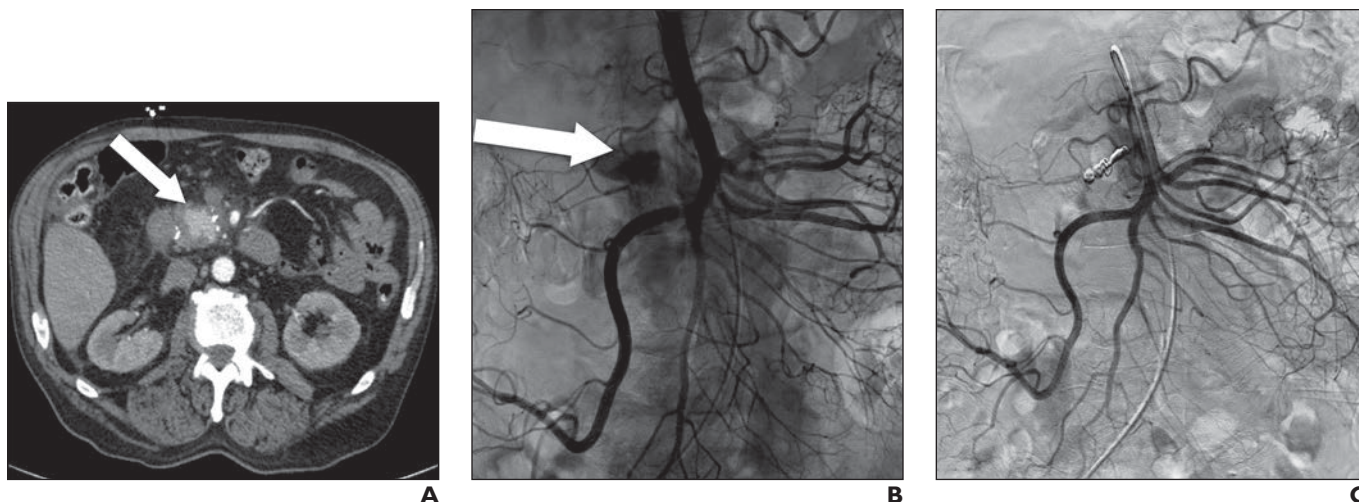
72-year-old man with history of pancreatitis who presented with black stool and decreased hemoglobin level. A, Arterial phase axial CT shows 3.2-cm pseudoaneurysm (arrow) in small branch of superior mesenteric artery at pancreatic head. B and C, Angiographic images show pseudoaneurysm (arrow, B) before (B) and after (C) embolization.
